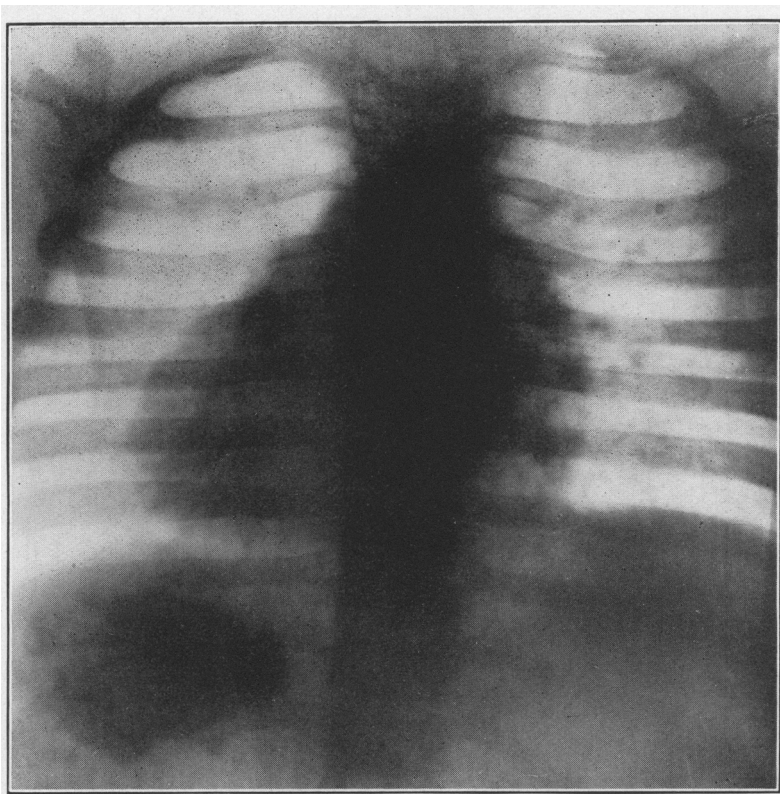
Same case. Roentgen picture taken after bismuth meal, following treatment by dilatation, showing that the bismuth has passed freely into the stomach.
